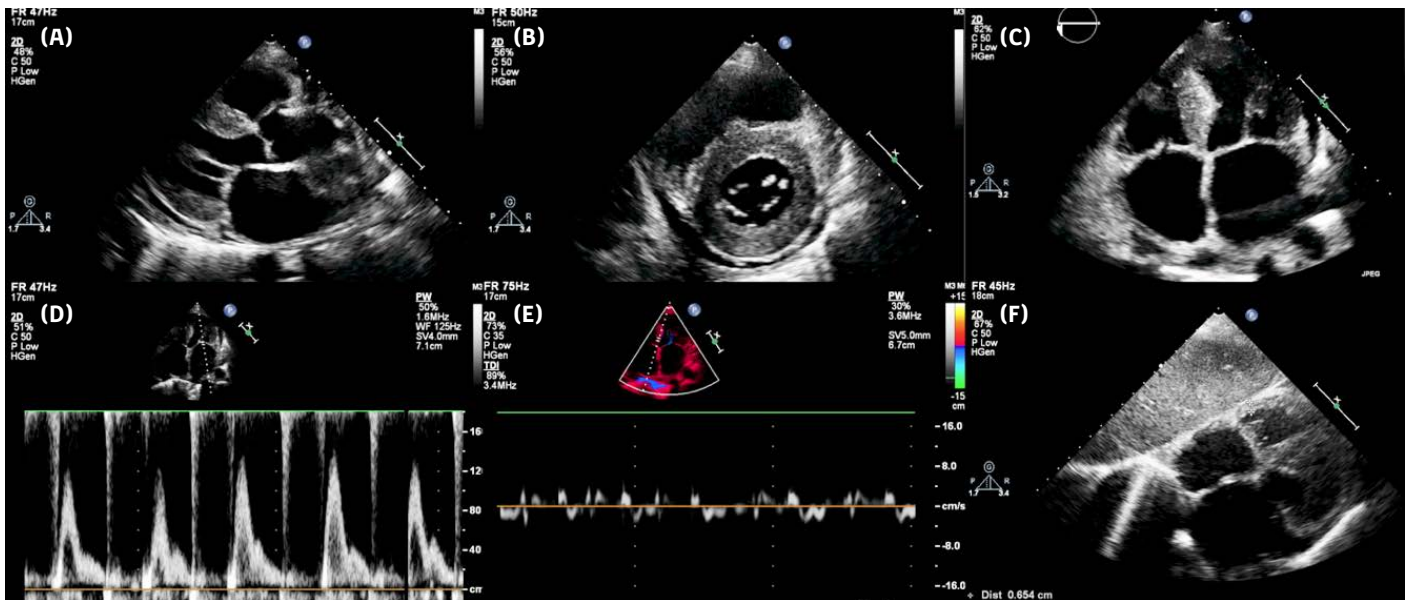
Echocardiography: (A) Parasternal long-axis view; (B) Parasternal short-axis view; (C) Apical four-chamber view; (D) Mitral inflow velocities; (E) Tissue doppler velocities; (F) Subcostal view.
